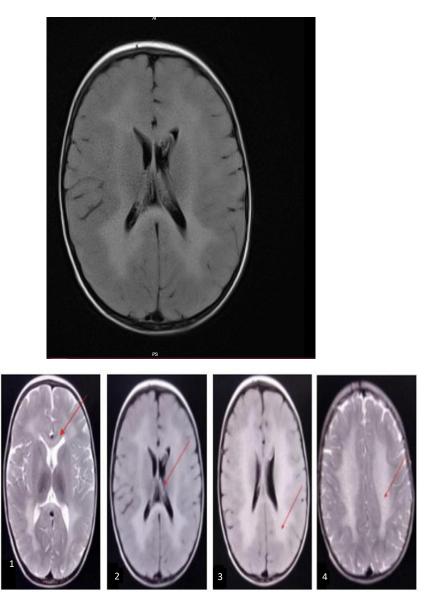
Magnetic resonance imaging (MRI) of the brain (T2) showing hyperintensities in bilateral periventricular white matter and corpus callosum. There is sparing of subcortical "U" fibres.
